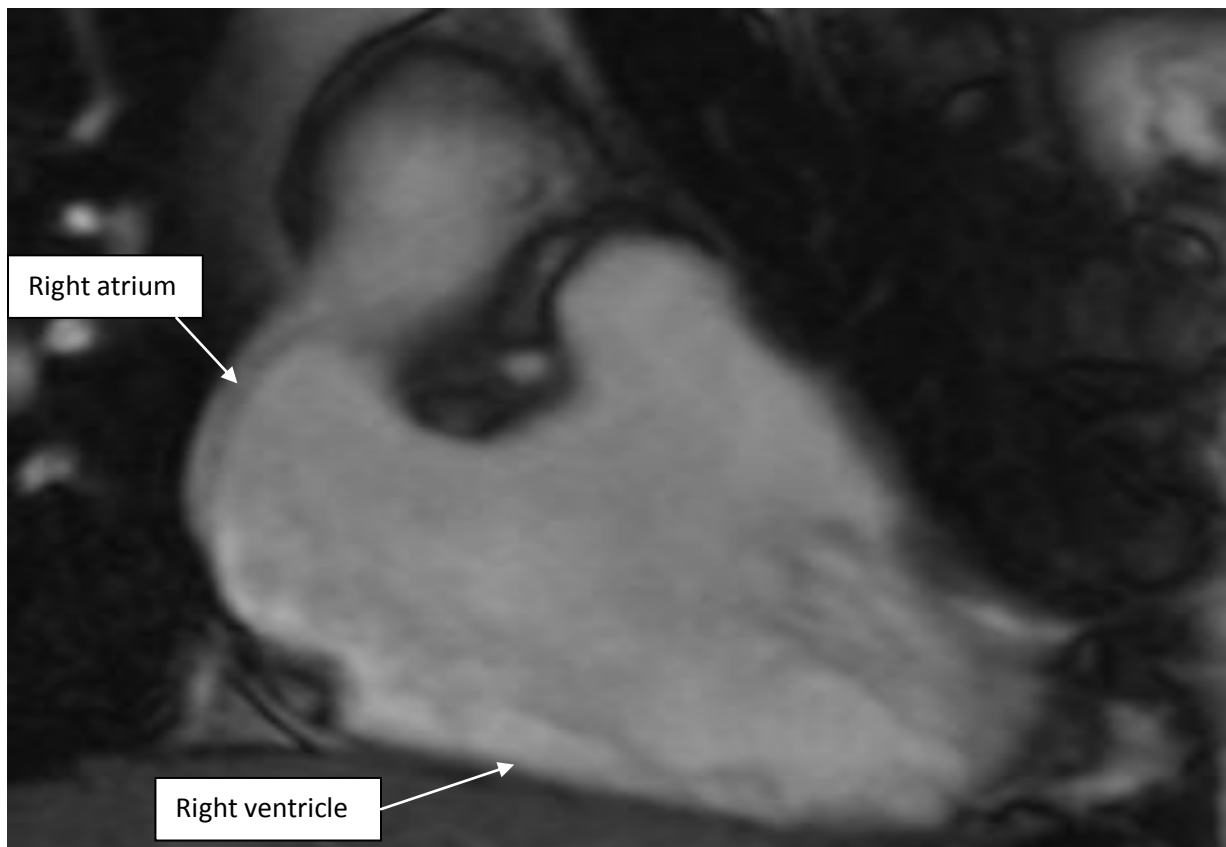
MRI CINE two chamber view (vertical long axis view) of right ventricle at diastole
